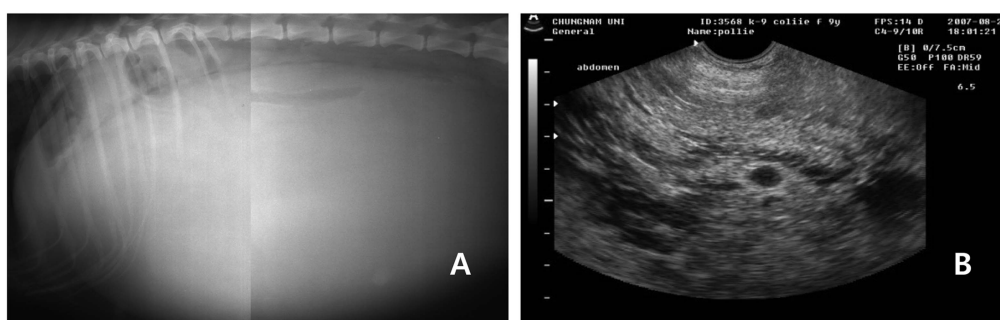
Cranial displacement of the liver and lateral displacement of intestines is observed in abdominal radiograph (A, right lateral view). Abdominal ultrasonography of the mass revealed many cysts, irregular surface and hypoechoic content (B).
